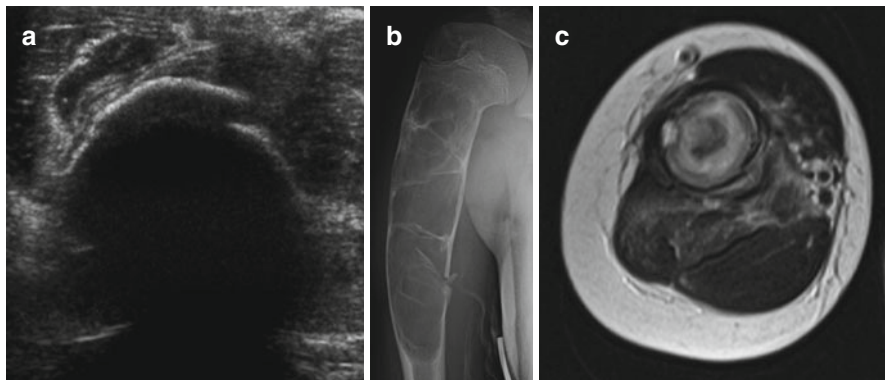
A young female patient with a history of a known juvenile bone cyst presenting with acute pain after a fall. (a) US shows irregularity of the cortical zone. (b) Anteroposterior view of the right shoulder confirmed the cyst rupture with cortical interruption. (c) Axial T2-weighted image highlights the presence of a double-density fluid-level lesion within the bone, associated with an inhomogeneous intensity of adjacent soft tissue, appearing edematous and inflamed
